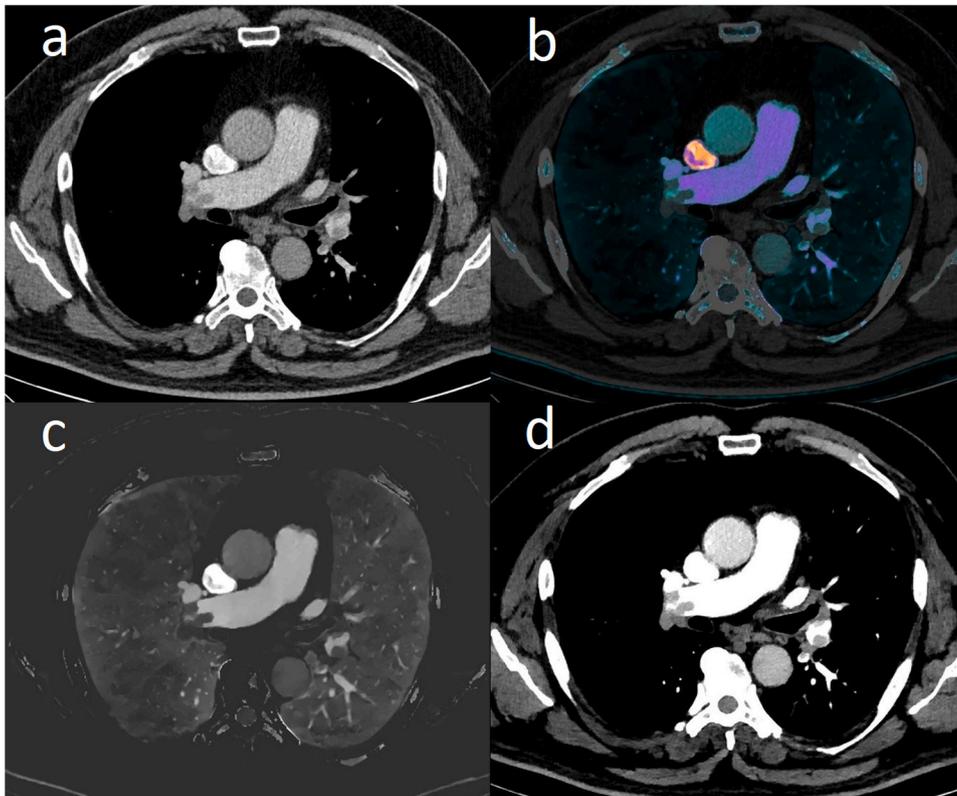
CT image of pulmonary embolism in COVID-19 negative patient. a. Conventional (Hounsfield unit) CT image. b. Fusion of iodine density maps and conventional image. c. Iodine density – perfusion map. d. Virtual low-energy monoenergetic image (55 keV). Visible are contrast filling defects of main right pulmonary artery spreading to lobar branches and in the left lobar/segmental branches.
